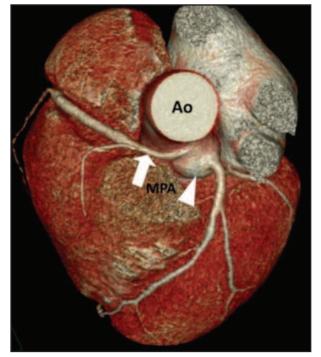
A 3D volume-rendered CT angiography displaying an anomalous of origin and course of RCA (arrow), originating from the LCS (arrowhead) and with an interarterial course. Ao = aorta, MPA = main pulmonary artery.
